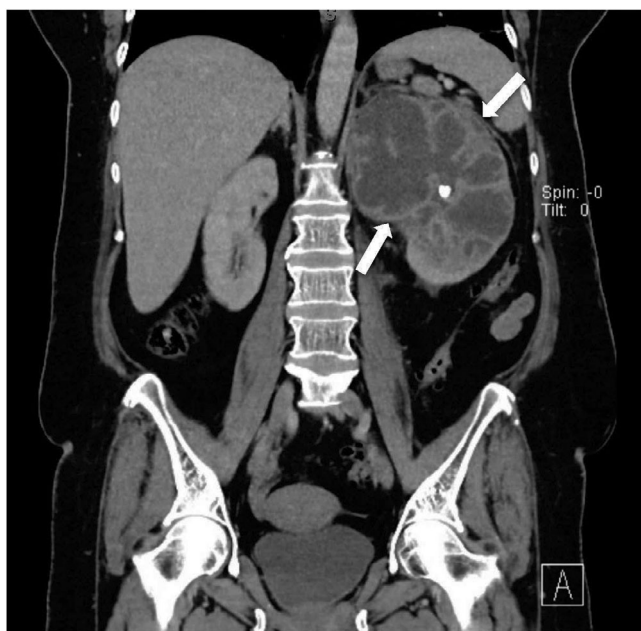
Coronal computed tomography (CT) of the abdomen and pelvis again displaying a left kidney (white arrows) with multiple fluid filled locules and thick septations, most notably involving the mid and upper portions with the stone again seen in the infundibulum.
